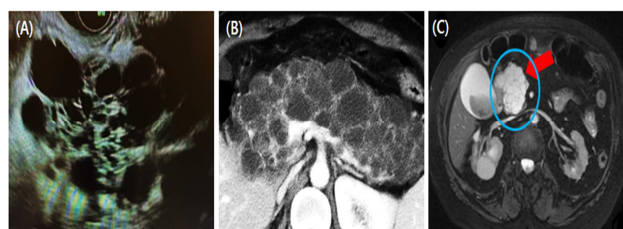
Characteristics of pancreatic cystadenoma by imaging. (A) Endoscopic ultrasound (EUS): EUS provides high-resolution images and is useful for evaluating the internal features of a cyst and guiding a biopsy if necessary, (B) CT scan: A characteristic "honeycomb" appearance is often seen, with multiple small, well-circumscribed cysts. The lesions are usually homogeneous and lack solid components, (C) Contrast-enhanced MRI: Magnetic resonance imaging (MRI) can provide detailed images and is useful in confirming the diagnosis. Serous cystadenomas appear as polycystic lesions with clear fluid contents. Endoscopic ultrasound (EUS) is also a valuable tool, providing high-resolution images and guiding biopsy when necessary. However, in most cases, the diagnosis can be made through imaging alone, and biopsy is rarely required[13].
